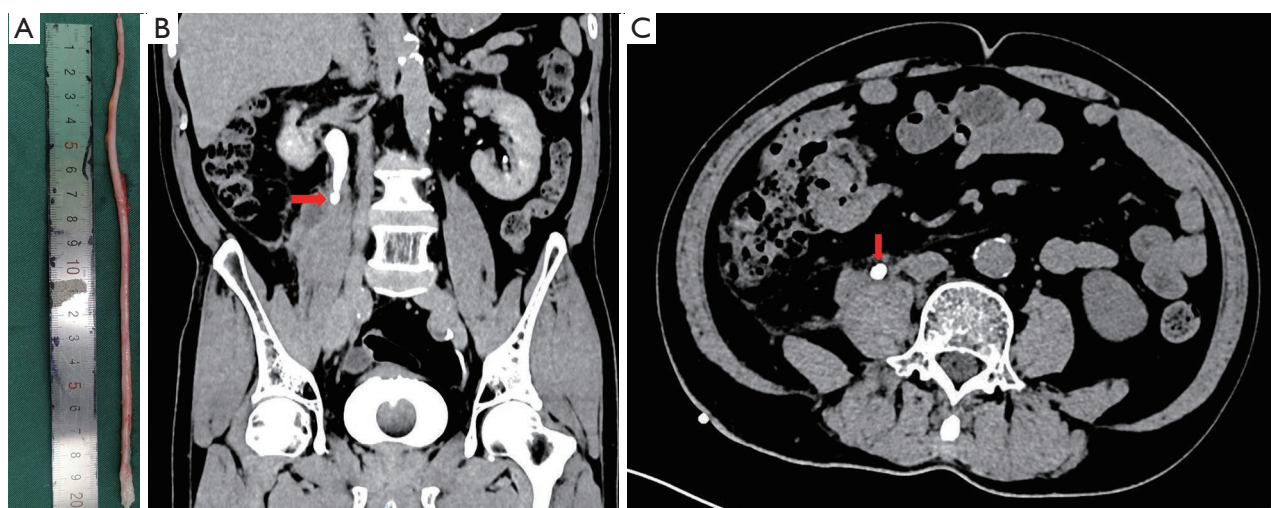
Avulsion of ureter and CTU. (A) The 20 cm right ureteral avulsion. (B,C) The coronal and axial planes of CTU show the presence of ureteral calculi (red arrows) and absence of the middle and distal ureter. CTU, computed tomography urography.
